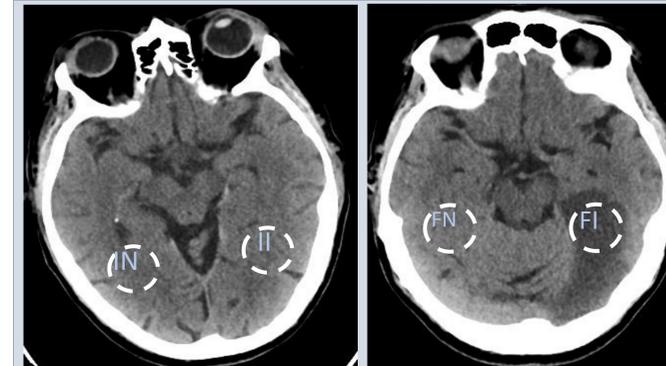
An initial and follow up CT head scan showing progression of an ischaemic stroke. IN= Initial normal side, II= infarct side on the initial scan, FN= Normal side on the follow up scan, FI= Infarct side on follow up scan
